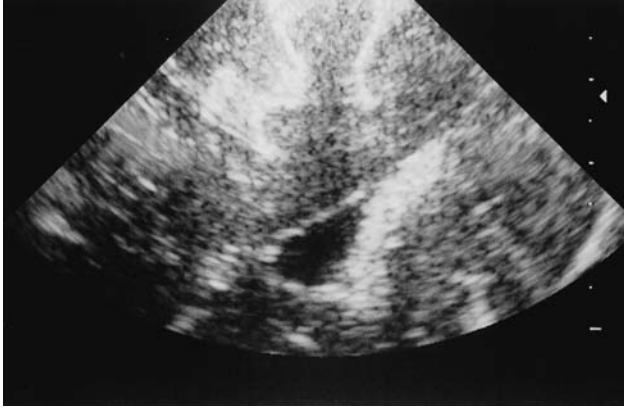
Intraoperative coronal ultrasound visualizing the atria of the lateral ventricle and adjacent hyperechoic choroid plexus.
